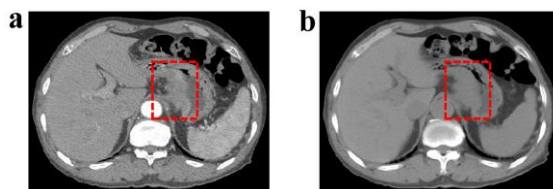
Examples of a) arterial phase CT and b) pre-contrast phase CT. The tumors are framed by red boxes.
